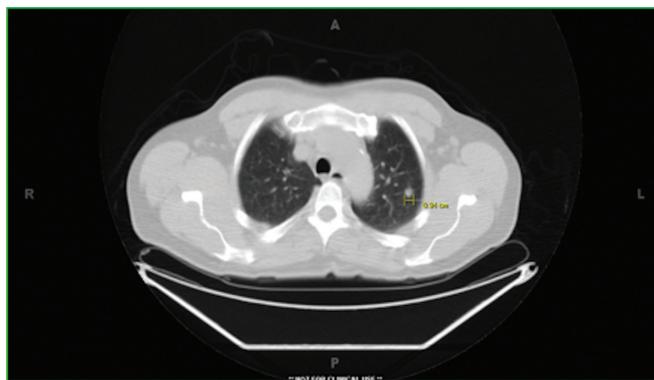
Computed tomography of a patient with a small lesion that pathology showed to be a moderately differentiated (G2) squamous cell carcinoma with a stage of T1N0Mx.
